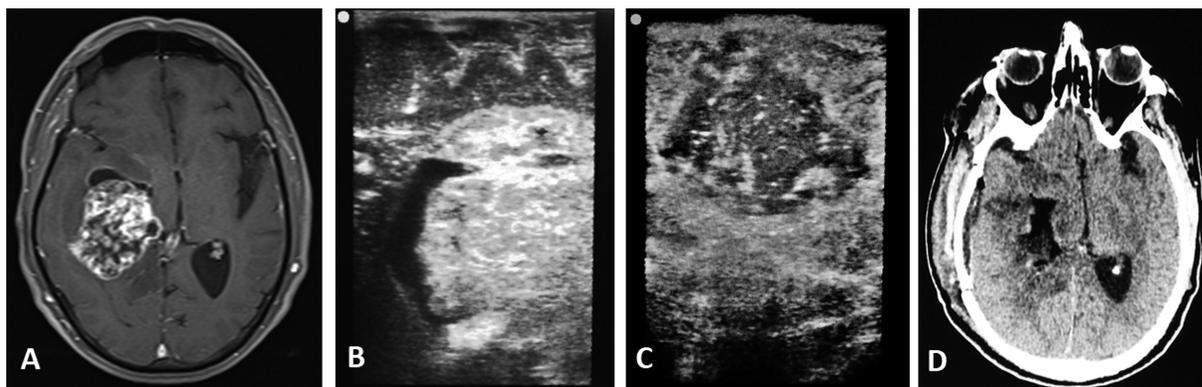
(A) T1-weighted magnetic resonance imaging (MRI) scan with gadolinium in the preoperative period, showing a heterogeneous temporal tumor with a cystic area. (B) Intraoperative ultrasound (IOUS) scan showing the tumor with heterogeneous appearance and the cystic area, similar to the preoperative MRI. (C) The IOUS for final resection control showing gross total resection. (D) Immediate postoperative computed tomography (CT) scan confirming gross total resection.
